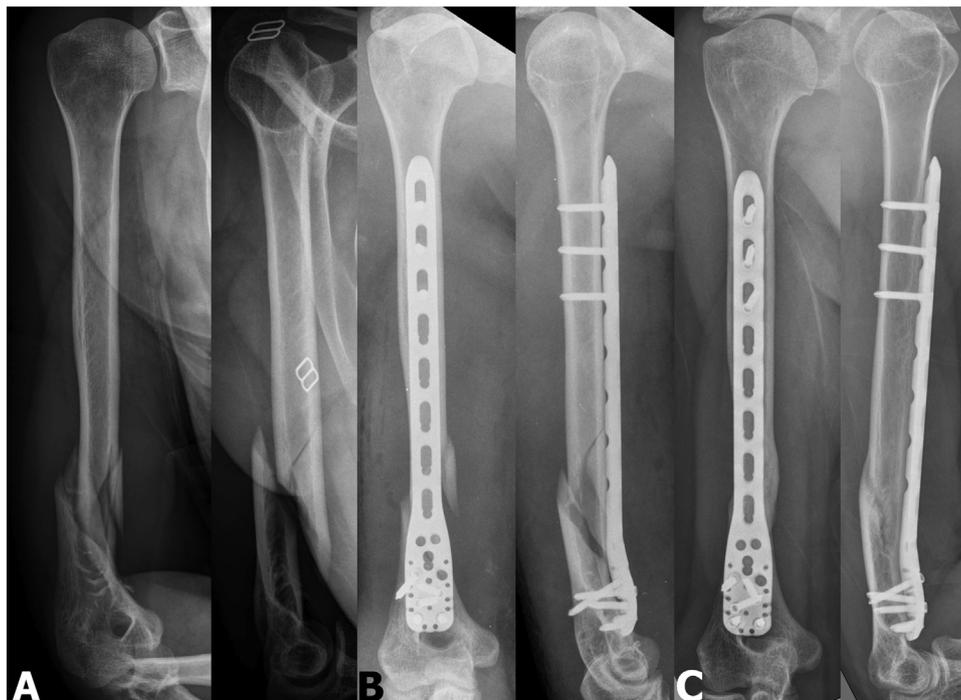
Extra-articular distal-third diaphyseal humeral fracture treated with the MIPO technique with modified use of the PHILOS plate. (A) A 47-year-old female with a 12B2 (c) fracture. (B) Immediate postoperative radiographs. (C) Radiographs 28 months after surgery showed bridging callus formation and solid bony union.
